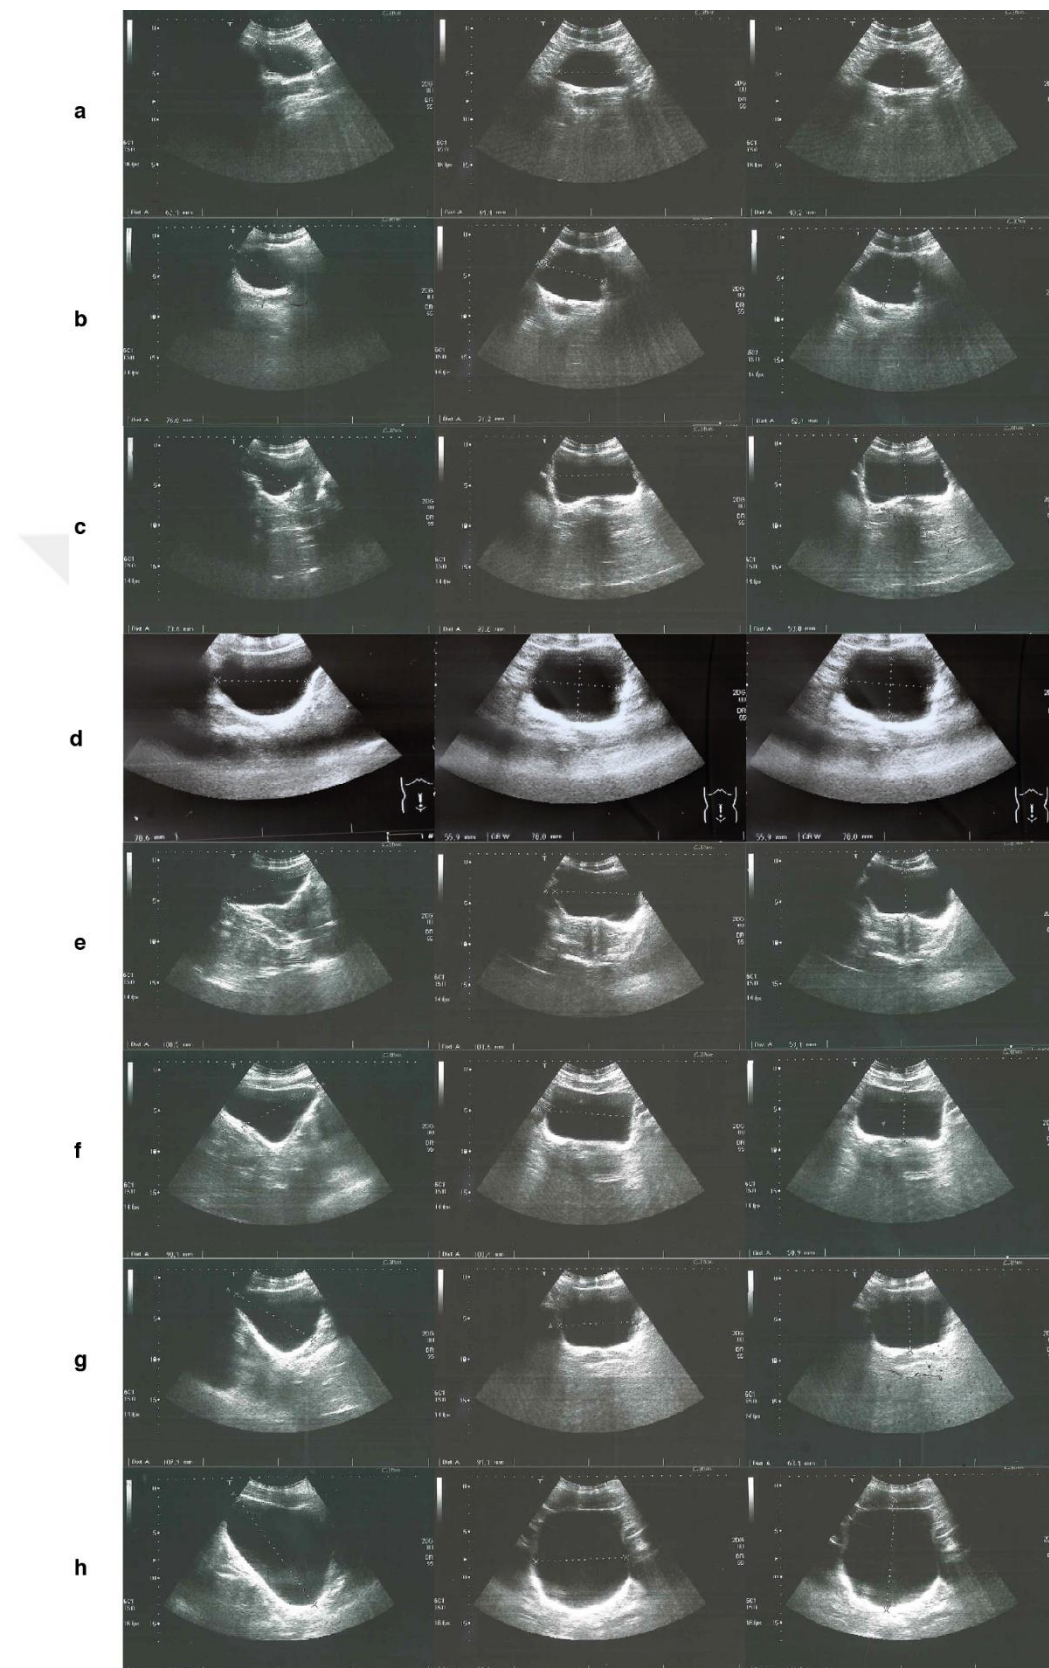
1: Ultrasound images of the volunteers' bladder taken by a doctor
